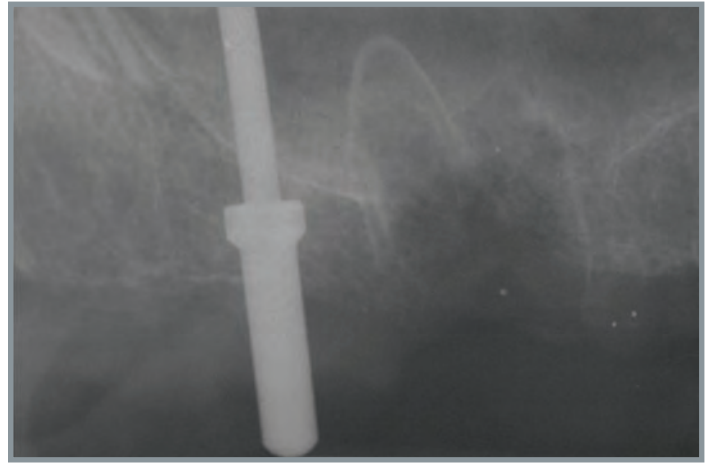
Periapical intraoperative radiograph. The initial drill is not angled enough to avoid maxillary sinus.
